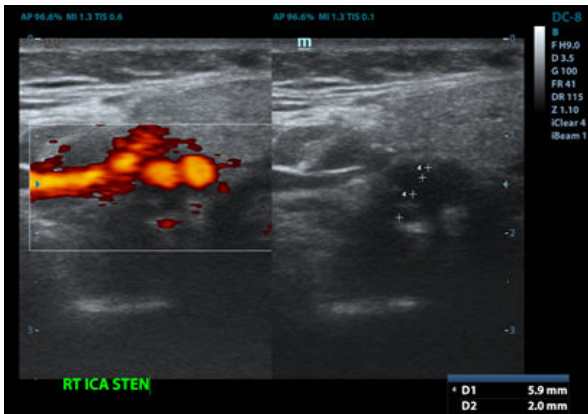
Carotid Doppler Showing Right ICA Stenosis
